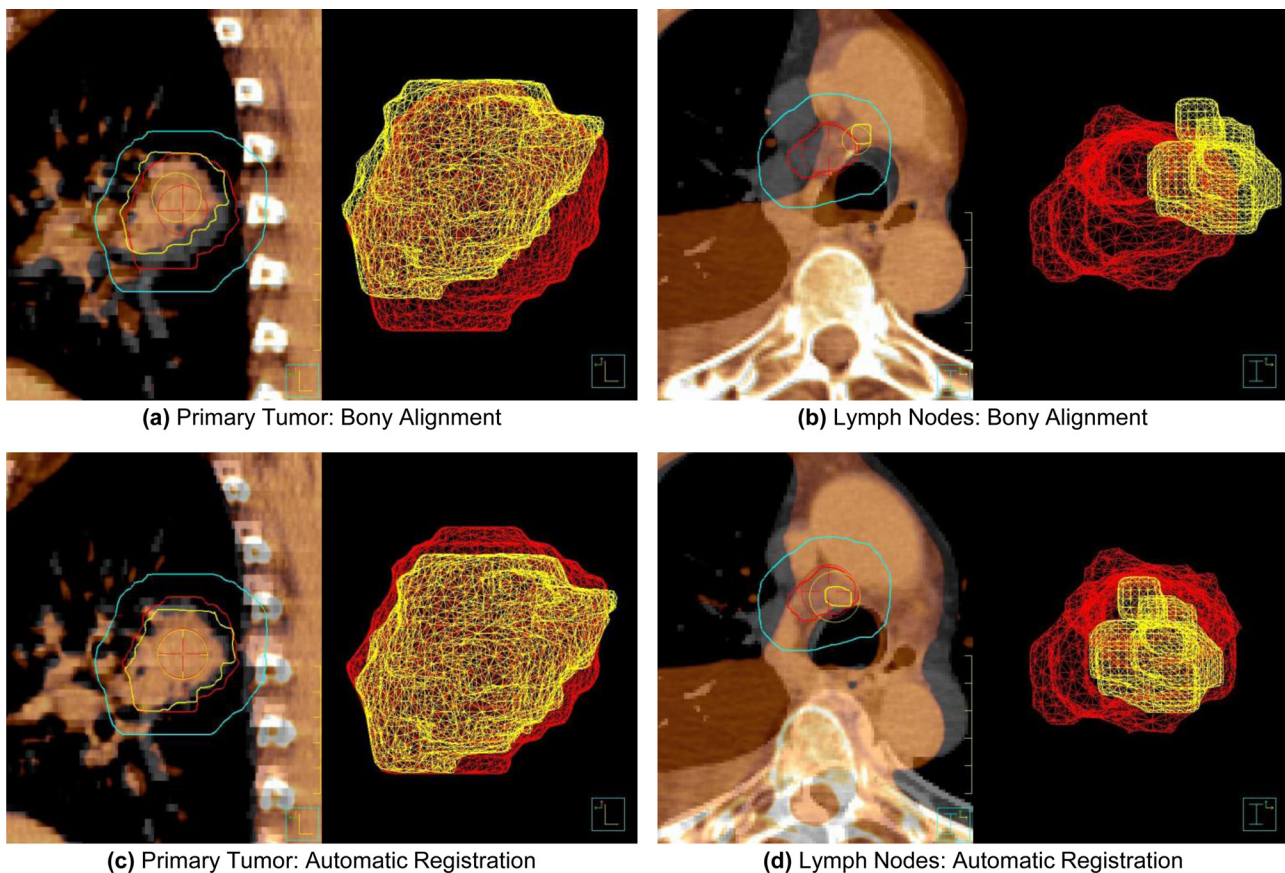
Overlay image showing the registration of targets from reference and secondary CTs from two different patients. Images were initially aligned using bony-anatomy (a)–(b). Pleural effusion likely contributed to the initial misalignment of an involved lymph node in (b). Automatic, rigid registration improved the localization of both the primary tumor (c) and involved lymph nodes (d) for patients in this study. The smaller surface meshes (foreground) represent targets from weekly CT images, whereas the larger surface meshes (background) represent targets from the initial planning CT. An additional contour is provided to demonstrate the registration volume obtained by a 10 mm isotropic expansion of targets from the planning CT.
